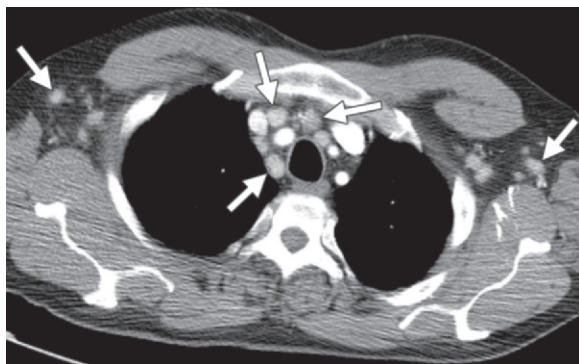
MCD in the same patient as in Figure 9, who presented with recurrent fever, chills, and bulky cervical, axillary, and inguinal lymphadenopathy. CT image shows diffuse, moderately enhancing axillary and mediastinal lymphadenopathy (arrows). A diagnosis of MCD was made with biopsy of an inguinal lymph node, with the patient having a CD4 count of 438 cells/ μ L at the time of diagnosis.
